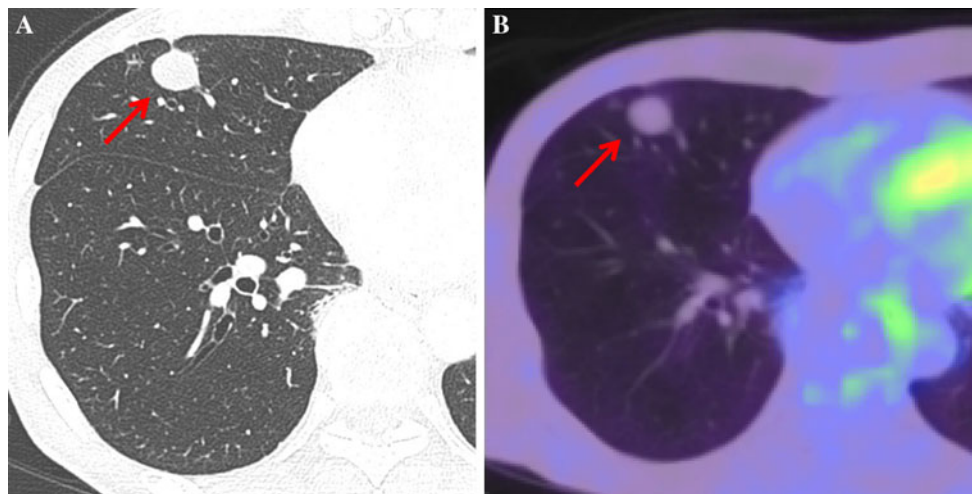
Thoracic CT shows a nodular shadow, 16 mm in diameter, in the right middle lobe (a). The nodule is circular and smooth, with clearly demarcated borders. No FDG uptake by the nodule is seen on
